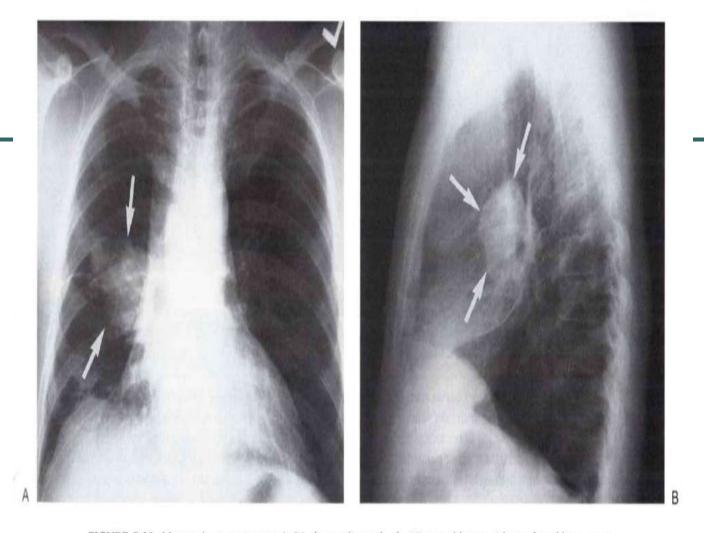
Metastatic osteosarcoma. A: PA chest radiograph of a 57-year-old man with cough and hemoptysis and a history of mandibular resection for chondroblastic osteosarcoma 7 years prior shows a large lobulated right hilar mass (arrows). B: Lateral view confirms the hilar location (arrows). (Continued)
